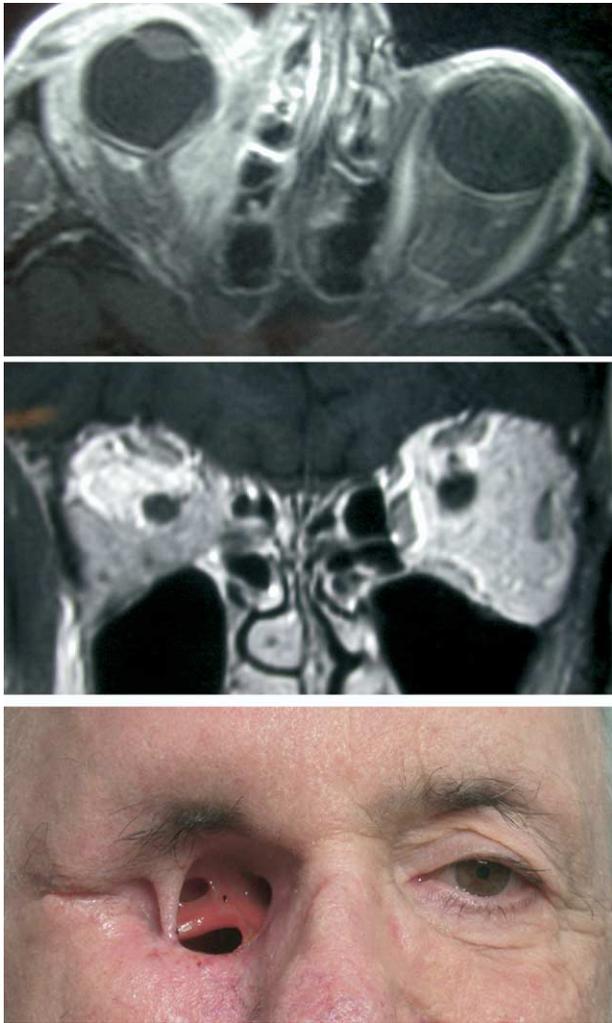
MRI scan of the orbits showing extensive medial basal cell carcinoma. Surgical cure is not expected. The patient underwent subtotal exenteration, with positive margins. Eyelid skin was spared, although this broke down over time leaving a lateral strand of skin.
